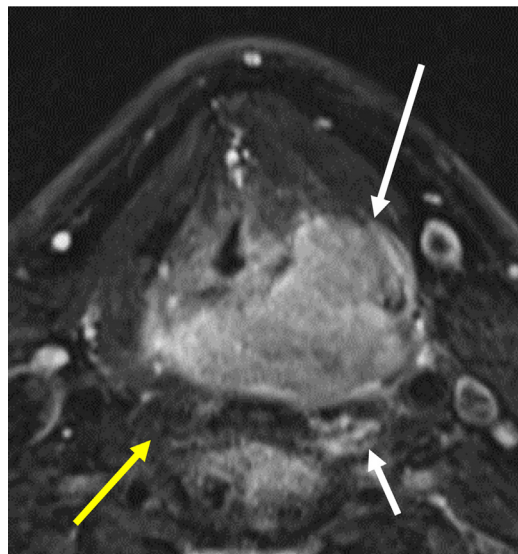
MR imaging findings suggestive of prevertebral muscle involvement. Axial T2WI obtained in a patient with a large pyriform sinus carcinoma (*long white arrow*) shows increased T2 signal in the ipsilateral longus coli muscle (*short white arrow*), which is suspicious for muscle involvement. Compare this with the normal appearance of the contralateral longus coli muscle (*yellow arrow*).
